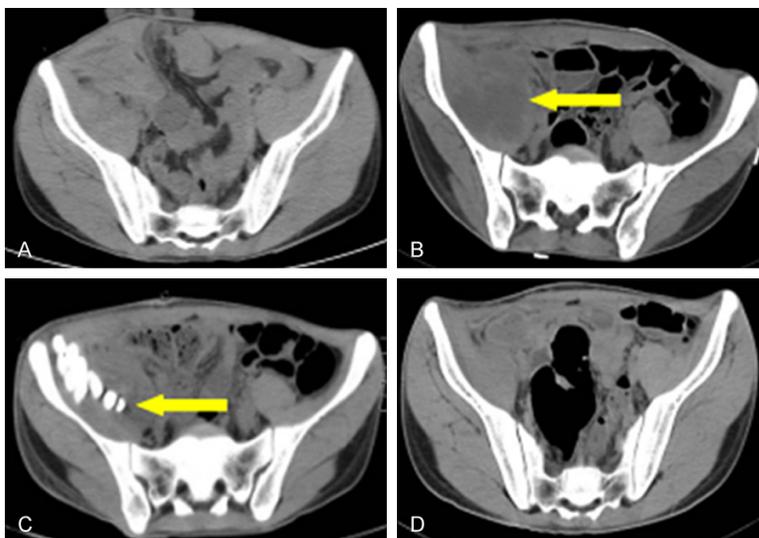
A: Abdominal CT at the time of admission; B: Abdominal CT at day 15 post-surgery showing iliopsoas abscess (indicated by arrows); C: Abdominal CT after clearance of the abscess, VSD drainage, antibiotic bead chain (indicated by arrow) three days after implantation; D: Abdominal CT after second debridement showing resolution of the iliopsoas abscess; VSD drainage and antibiotic bead chain was removed after one month of implantation. CT, computed tomography; VSD, vacuum sealing drainage.
